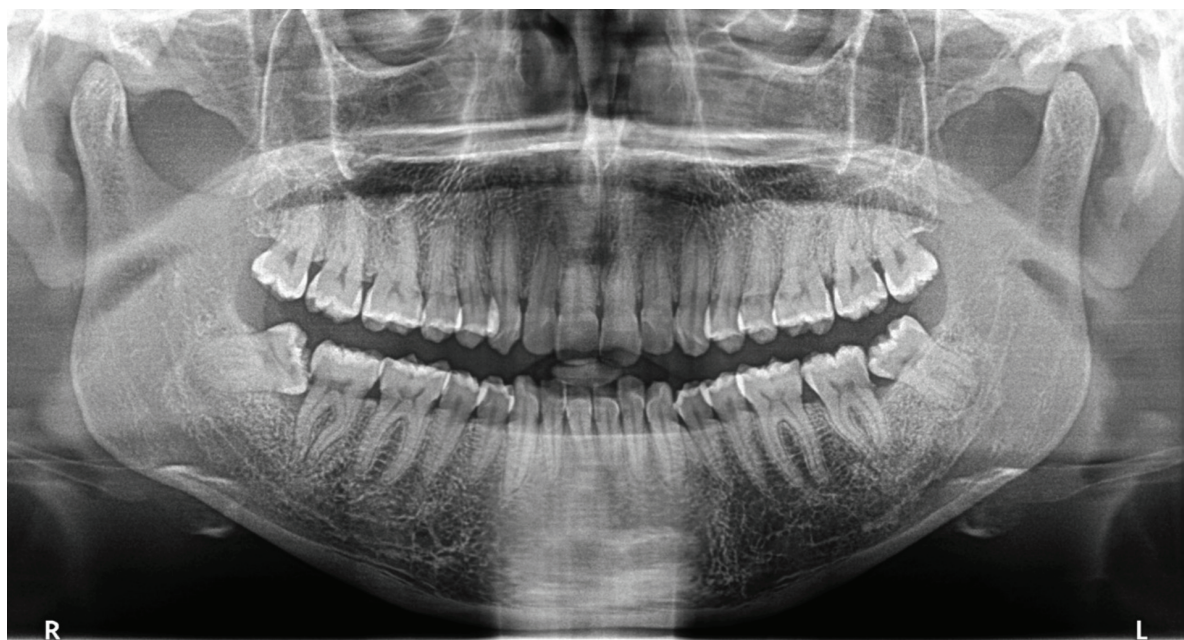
Preoperative orthopantomography of the lower left third molar extraction surgery.
